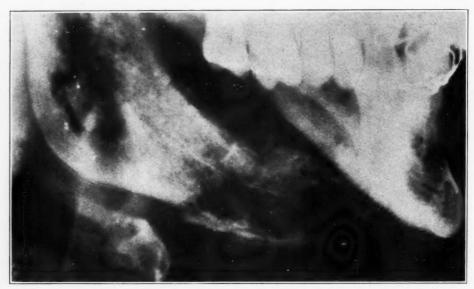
Roentgenogram made February 18, showing sequestrum in ramus and fracture of mandible, with beginning sequestration in bicuspid and molar regions.
